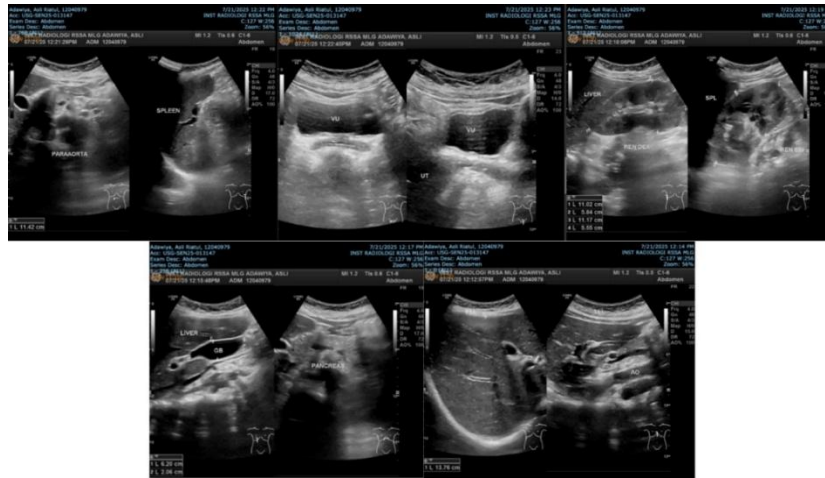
Abdominal ultrasonography showing no evidence of intra-abdominal metastasis, with mild left renal hydronephrosis likely secondary to post-renal obstruction.
